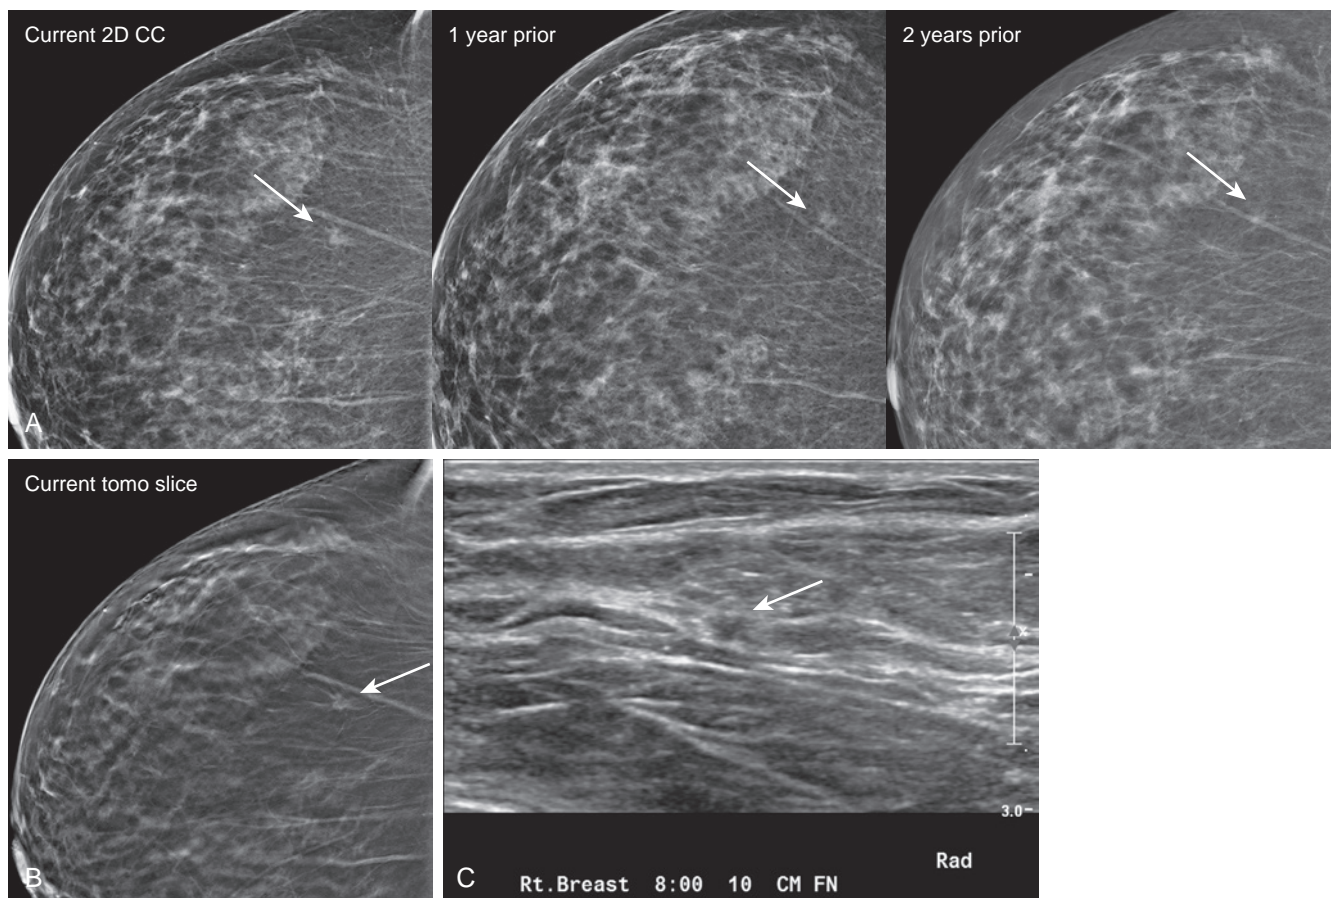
Developing asymmetry. (A) Close-up of a screening mammogram in a 70-year-old woman shows a focal asymmetry (arrows) posterolaterally in the CC view, which is noted to be developing compared with the prior 2 years' exams. (B) Tomosynthesis slice views show a small mass with spiculated margins. (C) Ultrasound correlate is a vague, ill-defined hypoechoic mass (arrow). Ultrasound-core needle biopsy and excision indicated well-differentiated invasive ductal carcinoma, with prominent tubular architecture; ER+, PR+, Her2-, pT1b N0.
